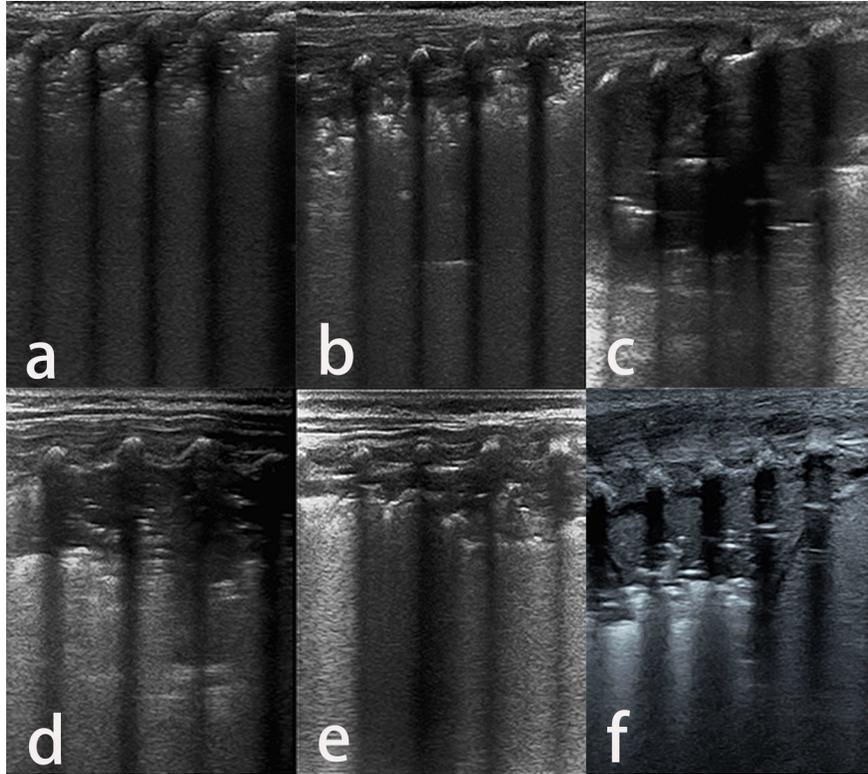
Lung ultrasound findings of severe pneumonia in neonates: a. *Pseudomonas aeruginosa* Pneumonia (nosocomial pneumonia); gestational age, 28 wk plus 3 d; b. *Streptococcus pneumoniae* (congenital pneumonia); gestational age, 41 wk plus 3 d; c. Pneumonia infected by *Staphylococcus aureus* and *Escherichia coli* (nosocomial pneumonia); gestational age, 28 wk; d. Respiratory syncytial virus pneumonia (community-acquired pneumonia); gestational age, 40 wk; e. *Chlamydia trachomatis* pneumonia (community-acquired pneumonia); gestational age, 38 wk plus 2 d; f. *Candida albicans* pneumonia (nosocomial pneumonia) gestational age, 27 wk plus 6 d.
